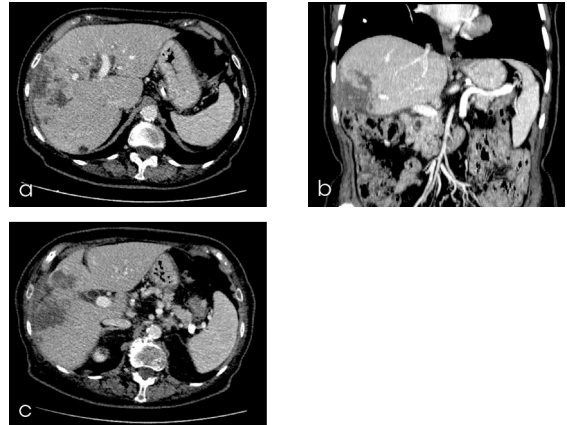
CT confirms complete response after third DSM-TACE at 6-month follow-up
